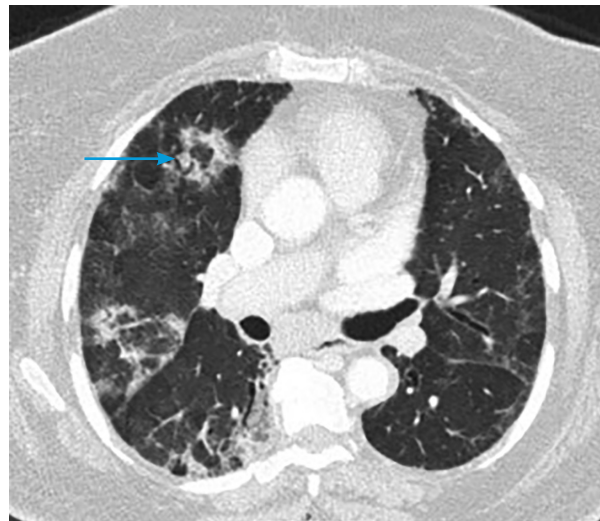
Computed tomography image demonstrating the reverse halo sign (blue arrow).
